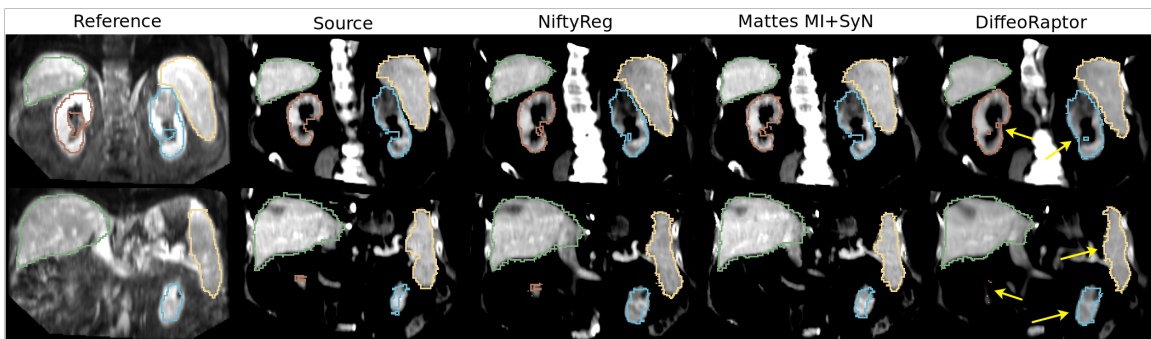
From left to right: coronal slices of Subject 7’s MRI (reference volume), the corresponding CT source volume, results of NiftyReg, Mattes MI+SyN, DiffeoRaptor, and NiftyReg respectively. Rows show different slices of volumes. Segmentations of key organs are shown with colored contours. Arrows are pointing to the regions where the image alignments are more visible.
